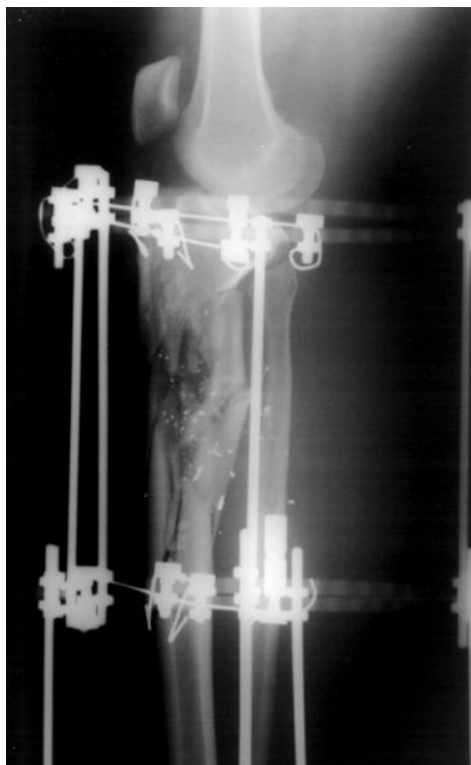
Anterior-posterior radiograph of severely comminuted gun-shot wound to the proximal tibia with Ilizarov external fixator in-place. Radiograph reveals good length and alignment.
